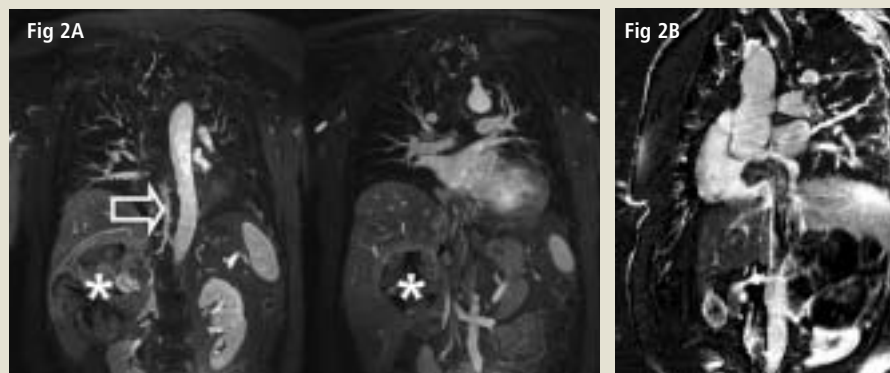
20mm thin MIP of the 3T-MRA (A) and 3T-phase-sensitive inversion recovery (PSIR) images of a patient with giant adrenal carcinoma. The carcinoma can be well depicted on the coronal MRA images (star, A) which was acquired after the administration of 15ml of Gd-BOPTA (Multihance). There is also tumour growth into the inferior vena cava and reactive dilatation of the azygos system (arrow). In the cardiac exam the extension of the thrombus into the right atrium is well demonstrated. As the MRI demonstrated that the thrombus was not attached to the atrial wall a surgical resection of the tumour was performed.
